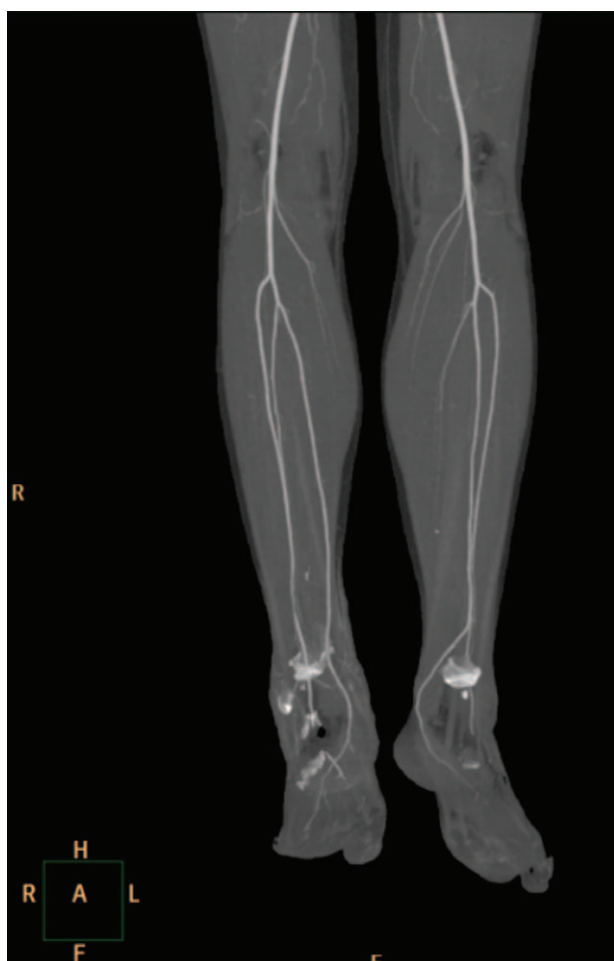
Computed tomography angiography of the lower limbs showed the filling defects of the bilateral distal posterior tibial arteries over the level of the ankles. The toes had collateral circulation from fibular arteries.
